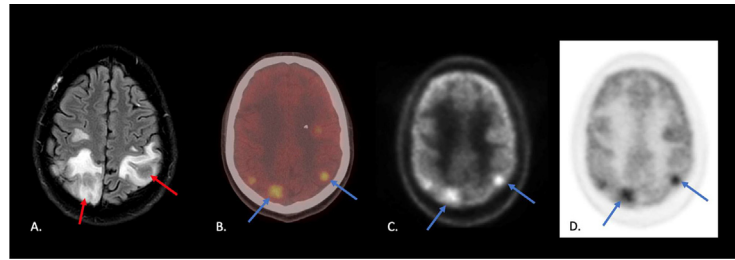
Column A is an axial section of a T2 FLAIR MRI of the brain, showing PCNS-PTLD lesions in the bilateral parietal lobes (red arrows) with significant surrounding edema. Columns B, C, and D show the corresponding FDG PET-CT axial sections, demonstrating focal FDG avidity within the intracranial lesions (Blue arrows).
